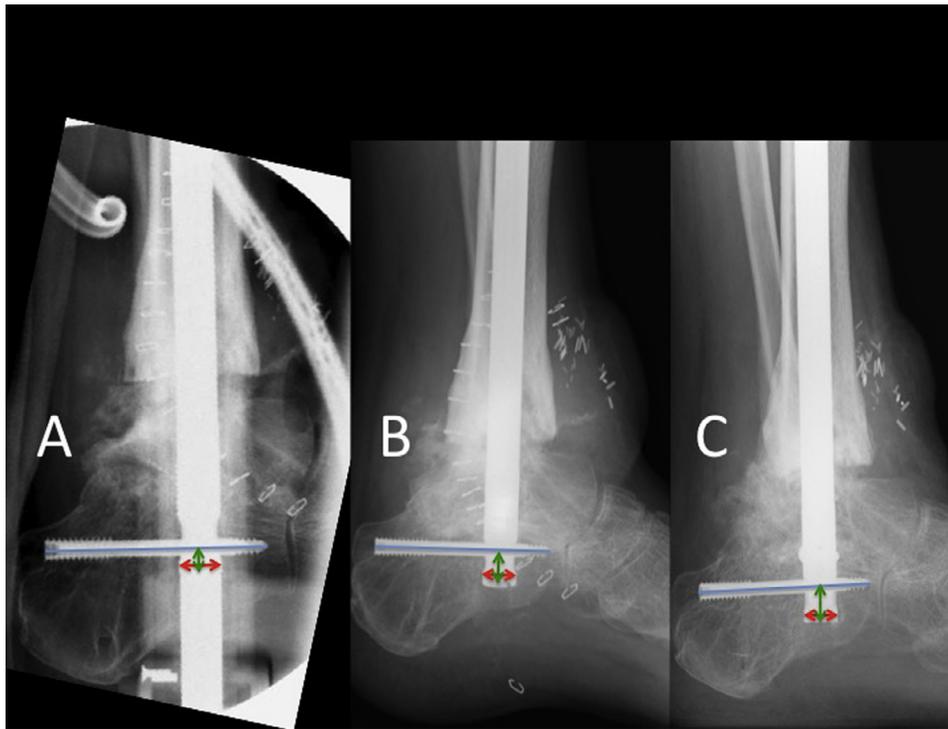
Method of radiographic measurements (patient SS). Consecutive intraoperative (A), 2-week postoperative (B), and 6-week postoperative (C) lateral ankle radiographs demonstrating positional change of the posterior-to-anterior screw within the dynamic compression hole owing to unloading of the internal nitinol compression element. The width of the base of the nail (red arrows) was used to calibrate images for measurement. The position of the posterior-to-anterior screw within the dynamic slot was then measured (green arrows), using the base of the nail and the center of the posterior-to-anterior screw (blue lines) within the midline of the nail as references.
